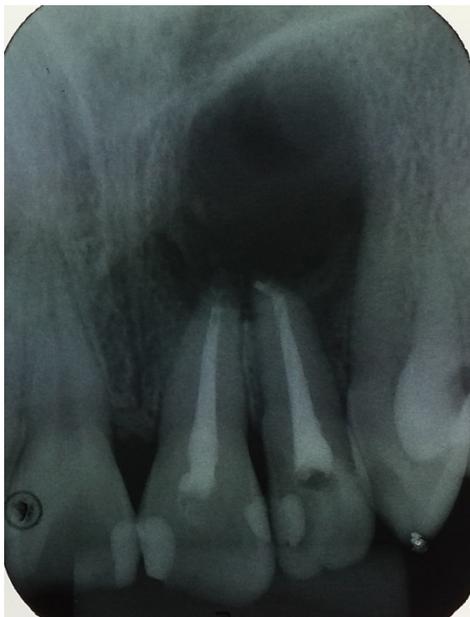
Periapical 7 days after apicoectomy.
